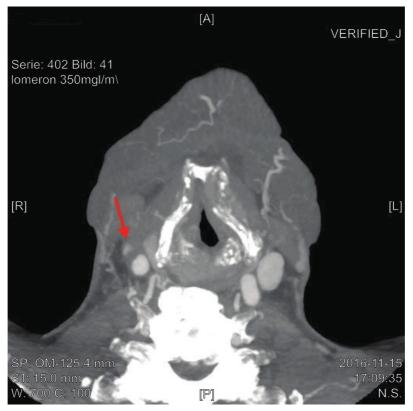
Contrast-enhanced CT with maximal intensity projection shows severe lumen reduction of the right internal jugular vein with decrease in contrast filling (arrow). The possibility of surrounding hematoma cannot be excluded. However, no contrast extravasation was seen.
